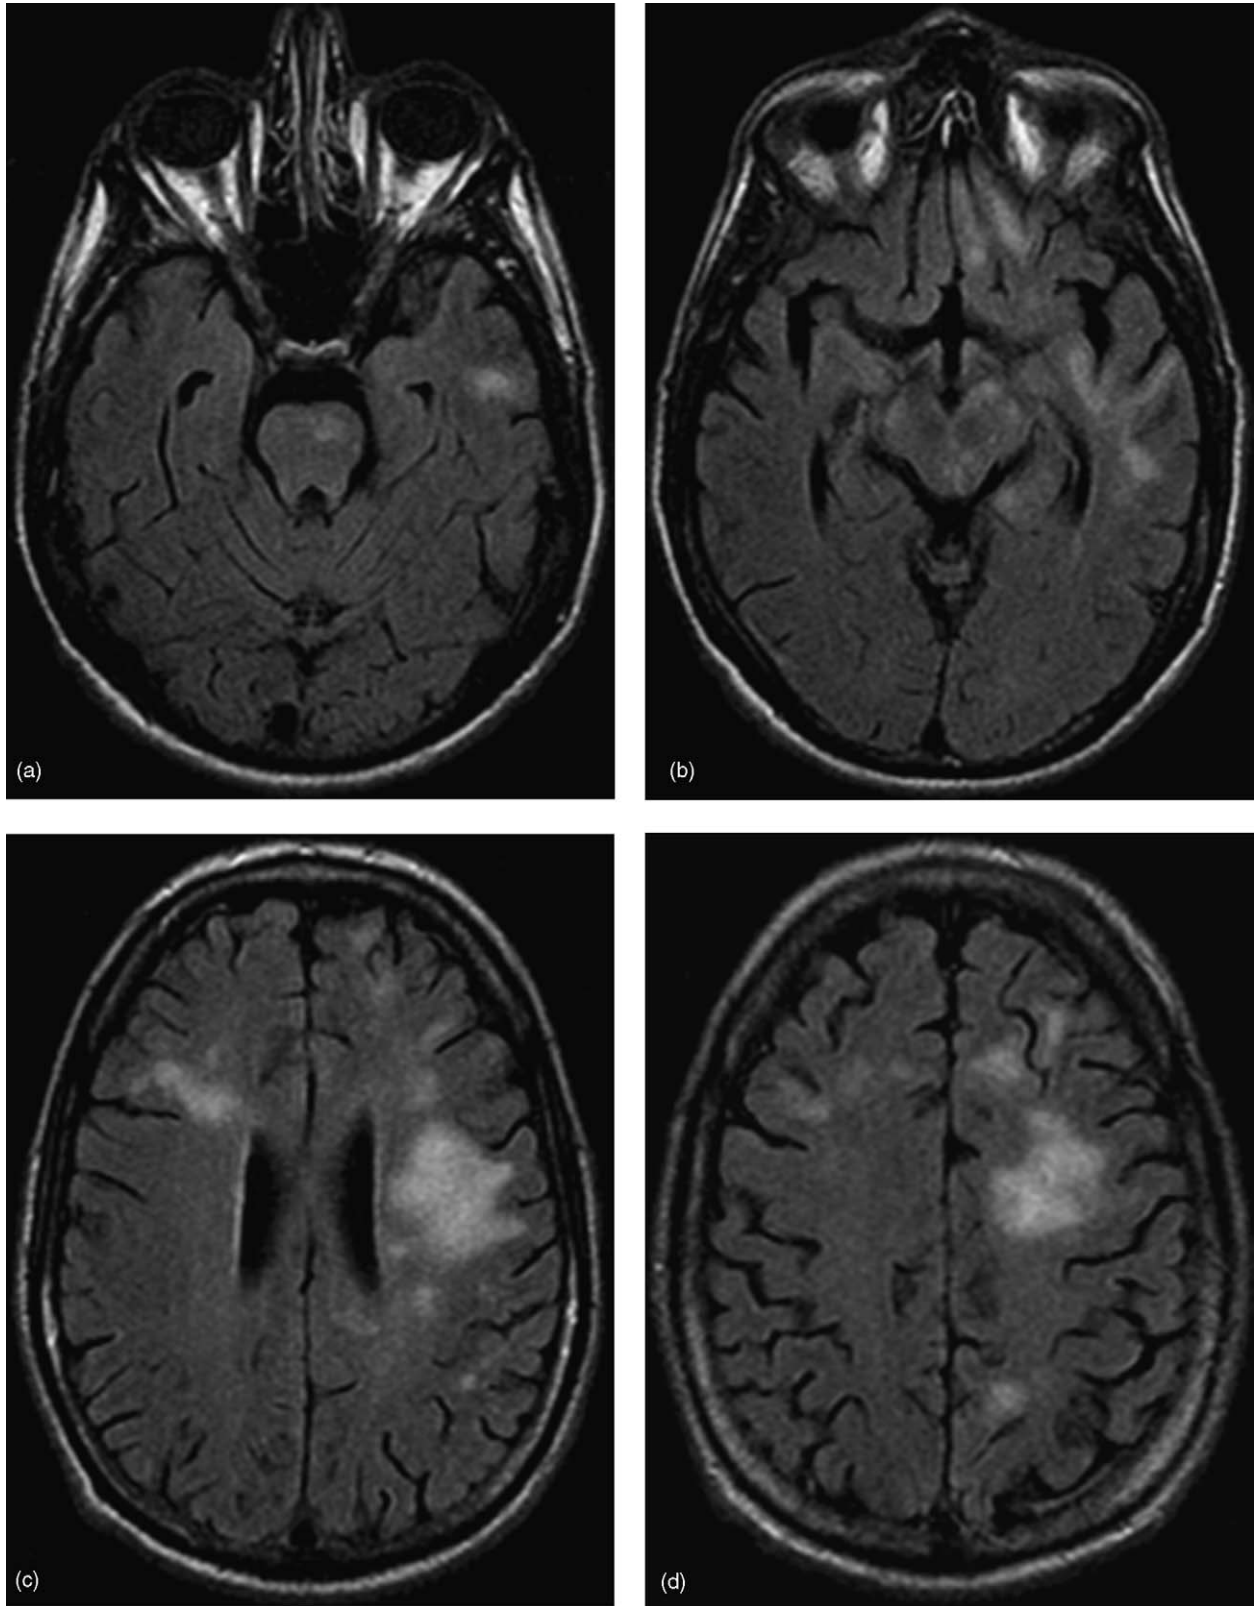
(a–f) T2 W and FLAIR images—multiple foci of hyperintensity on T2 and FLAIR in the sub-cortical white matter and left pons. No significant mass effect on adjacent sulci. Involvement of sub-cortical U-fibers gives a “scalloped” appearance to the lateral margins of the lesions.
